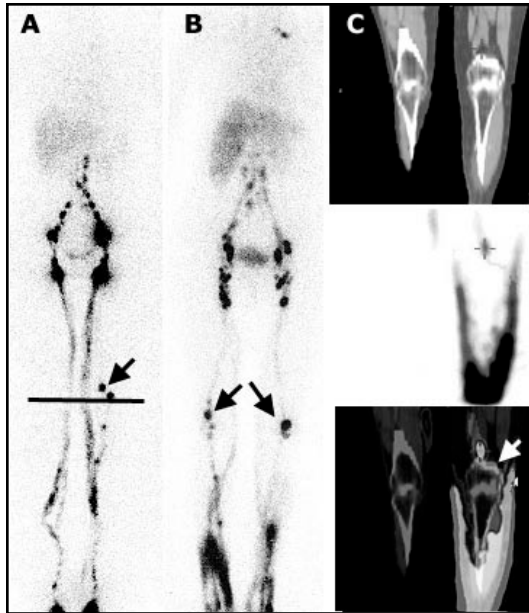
RNL staging. Stage L_{1B} : Uni- or bilateral slow lymphatic transport within the superficial and visualization of the deep lymphatic system as a compensatory route (A,B). Distal lymph stasis and no blockade. Normal inguinal lymph nodes and visualization a functional popliteal lymph nodes (black arrows). C: Visualization of the lymphatic pathway between the superficial and the deep lymphatic systems on the SPET-CT fusion image (white arrow).
